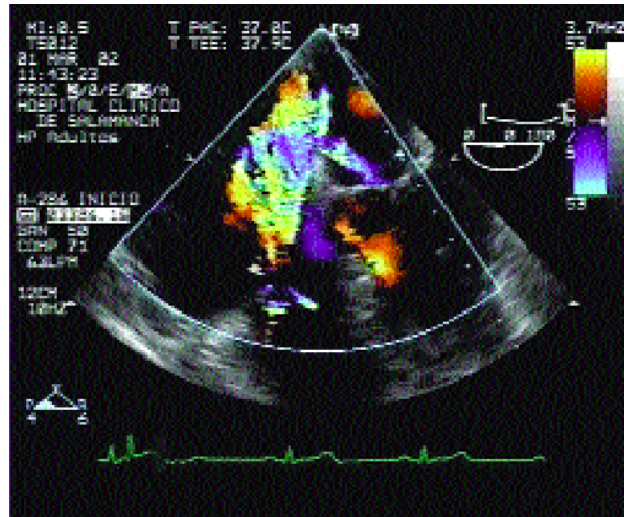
Transesophageal echocardiography of patent foramen ovale. A color Doppler echocardiography shows tricuspid regurgitation flowing toward the interatrial septum passing to the left atrium via the patent foramen ovale.
